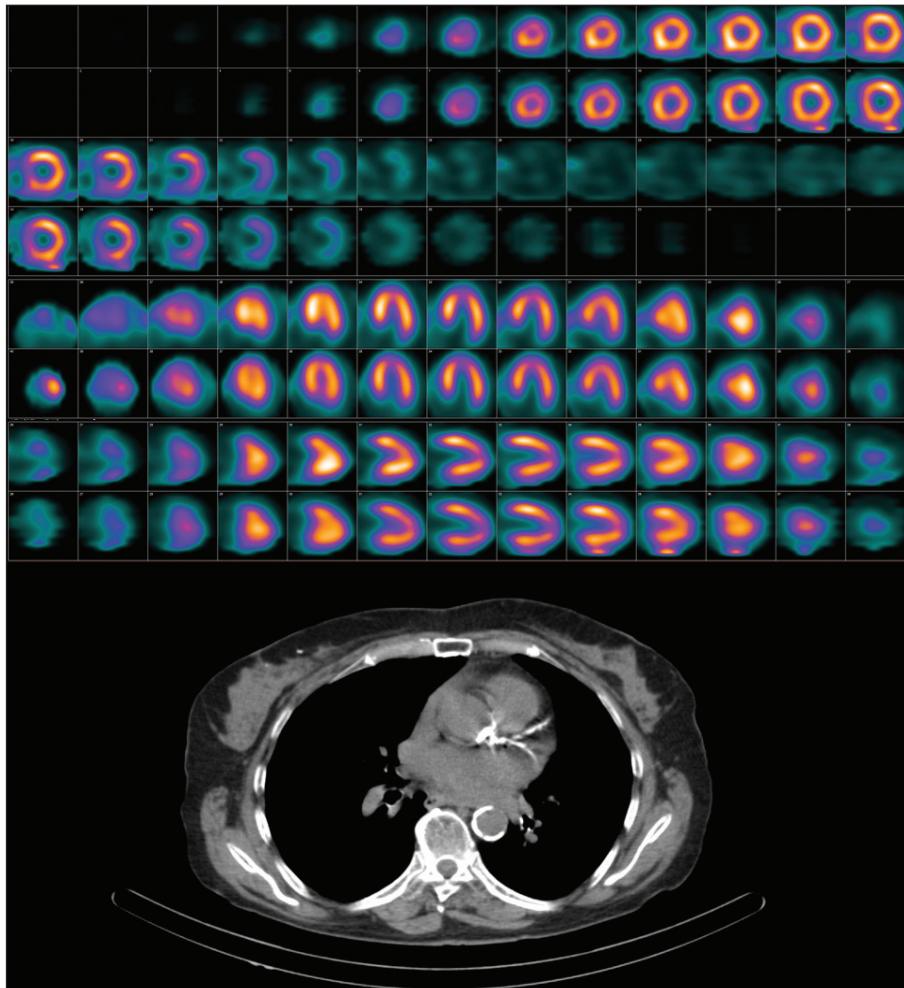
Coronary and thoracic aorta calcification were noted in a 73-year-old female patient with no evidence of ischemia on the stress myocardial perfusion scintigraphy.
